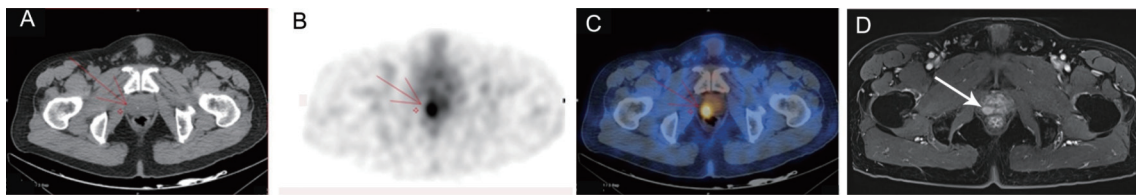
^{99m}Tc -PSMA SPECT/CT和MRI前列腺癌检查
